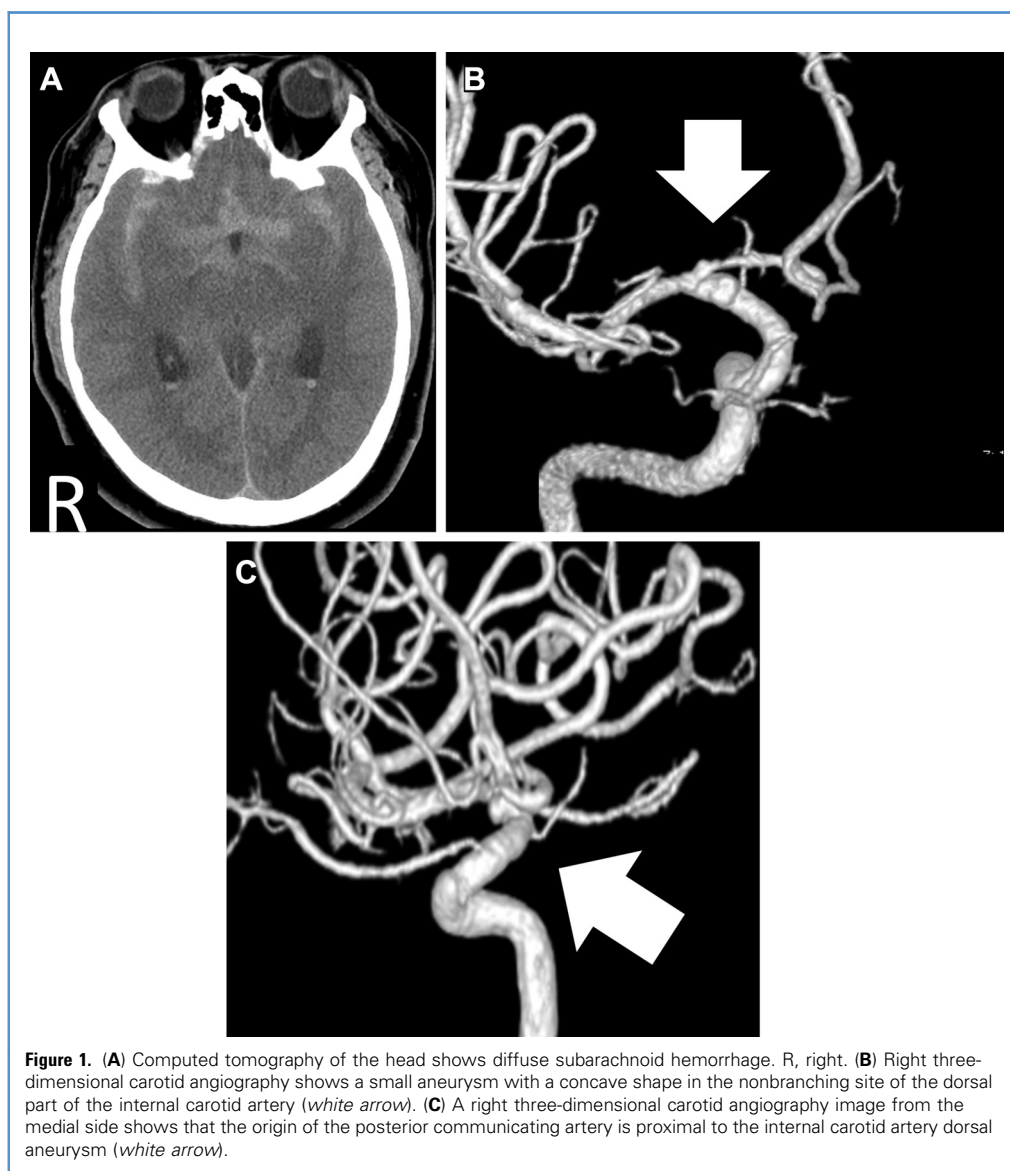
(A) Computed tomography of the head shows diffuse subarachnoid hemorrhage. R, right. (B) Right three-dimensional carotid angiography shows a small aneurysm with a concave shape in the nonbranching site of the dorsal part of the internal carotid artery (*white arrow*). (C) A right three-dimensional carotid angiography image from the medial side shows that the origin of the posterior communicating artery is proximal to the internal carotid artery dorsal aneurysm (*white arrow*).
